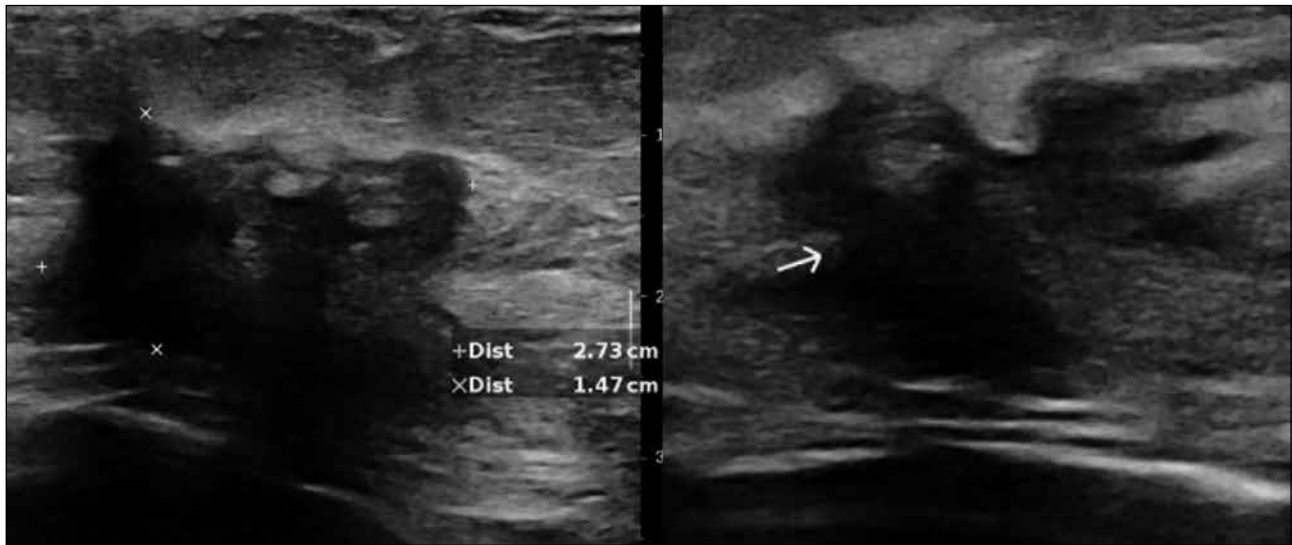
Ultrasound of the left breast mass showing significant posterior shadowing and invasion of the underlying pectoralis major muscle (arrow).
